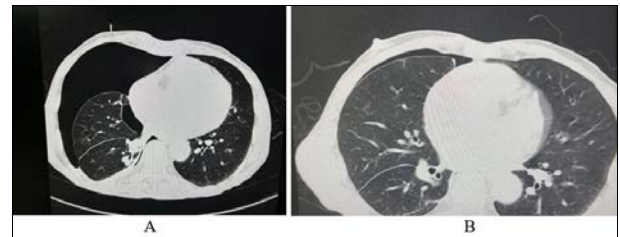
a, b: Depicting post biopsy pneumothorax was immediately aspirated under CT guidance using a simple 18G cannula, 3 way system and 50cc syringe in same sitting.
